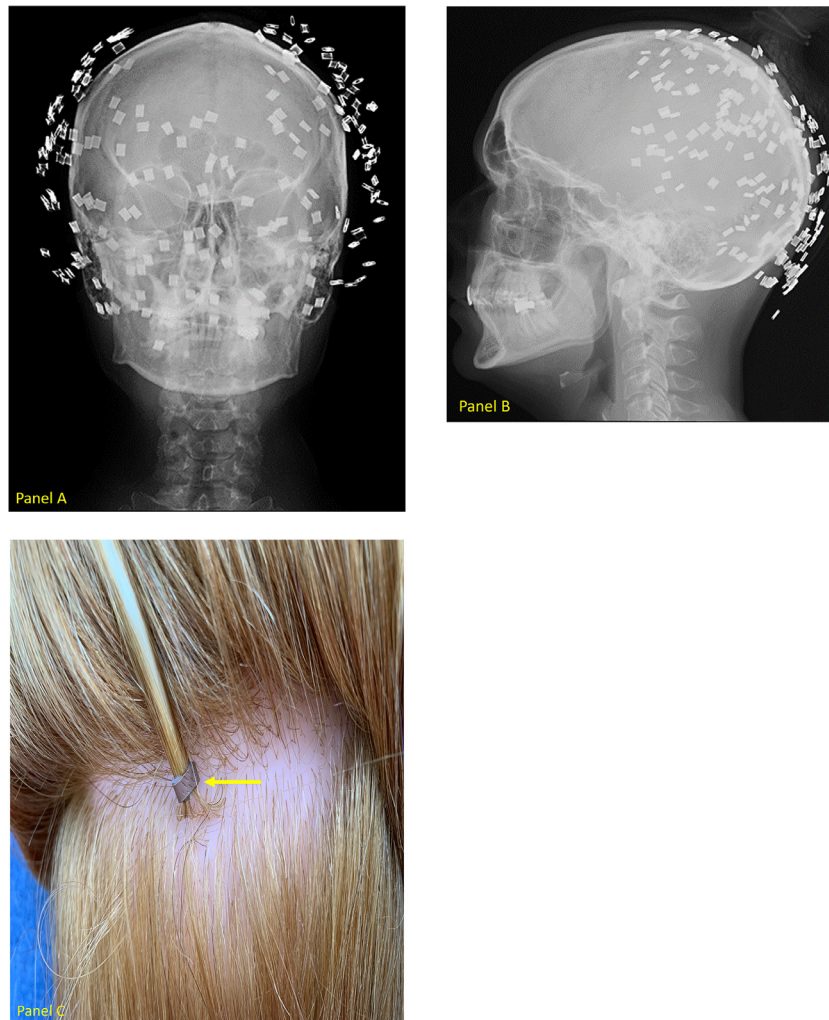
Coronal x-ray of flattened metallic microbeads (panel A), Sagittal x-ray of flattened metallic microbeads (panel B), Crimped metallic microbeads shown on mannequin (panel C).
